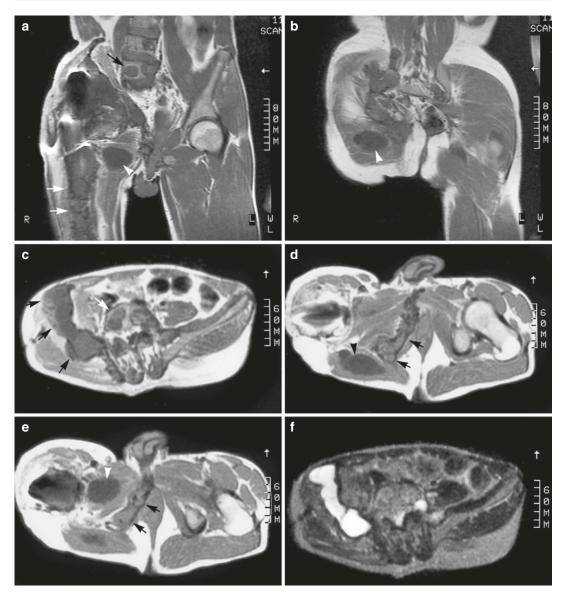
Multiple intramuscular myxomas with polyostotic fibrous dysplasia of bone of the lumbar spine, pelvic bones, and femur in a 35-year-old man. (a, b) Coronal spin-echo T1-weighted MR images at the level of the right femoral diaphysis (a) and gluteal muscles (b). (c–e) Axial spin-echo T1-weighted MR images at the level of the iliac wings (c), hips (d), and trochanteric regions (e). (f–h) Axial spin-echo T2-weighted MR images at the level of the iliac wings (f), hips (g), and trochanteric regions (h). The intramuscular myxomas appear as homogeneous, very low-intensity soft tissue masses within the right adductor (a, e) and gluteal (b, d) muscles (*arrowheads*). The areas of the right pelvic bones, right femur, and lumbar vertebrae that are involved by fibrous dysplasia have a
